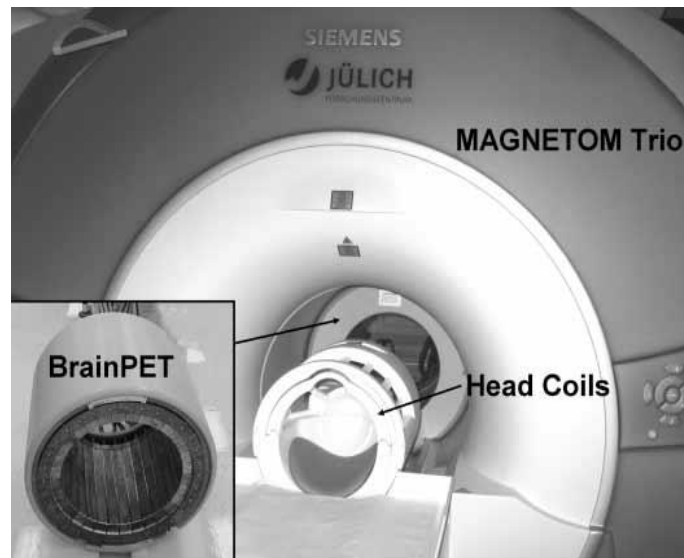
The 3T MR-BrainPET installed at the Forschungszentrum Jülich (since 2008). This hybrid scanner consists of a MAGNETOM Trio MRI and the BrainPET insert (placed between the magnet and the MR coils) [27].
